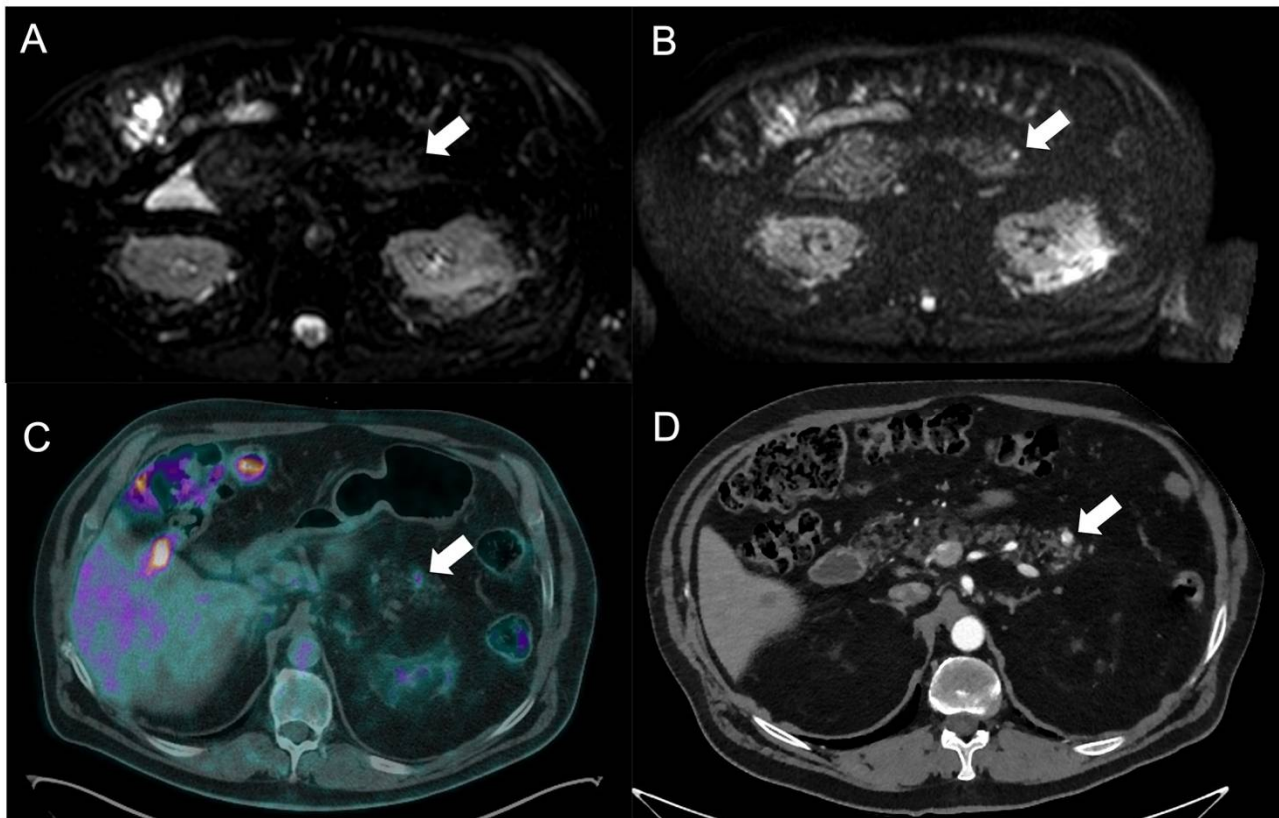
The pancreatic NEN lesion at the tail is highlighted with an arrow. DWI at low and high b-values, respectively, in Subfigures (A,B), showing the restricted diffusion detecting the little lesion, typically characterized by ^{68}Ga uptake in PET/CT (C) and high arterial enhancement at CT (D).
